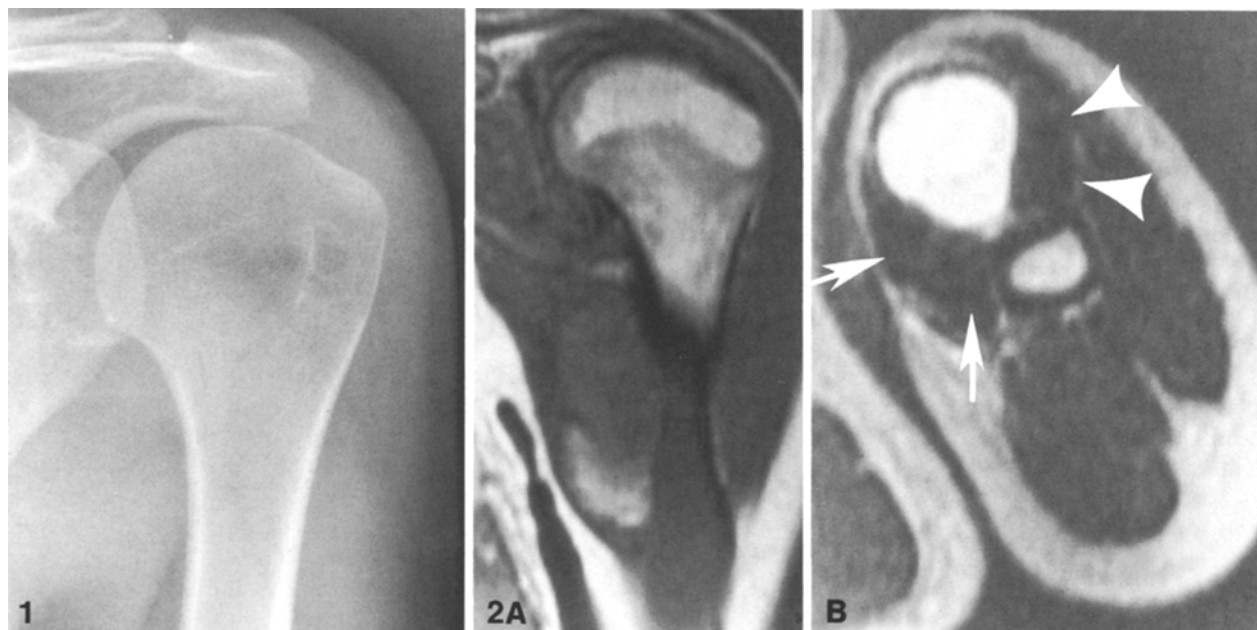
A plain radiograph shows a small non-specific lytic lesion with sclerotic margins in the humeral head between the tuberosities
